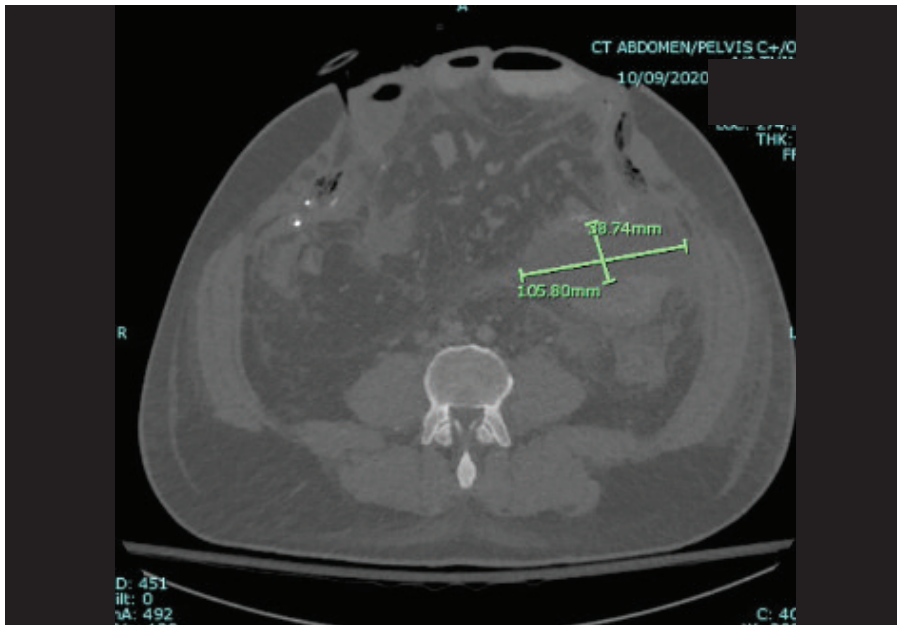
Pre-operative CT of the abdomen and pelvis.
